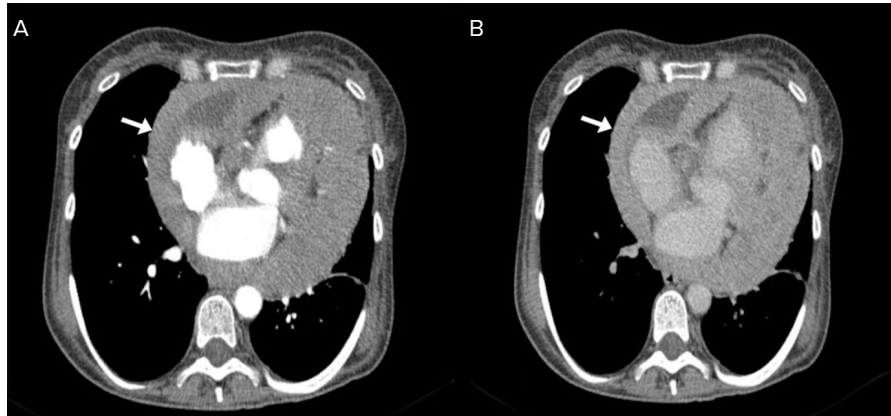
Contrast CT scan three months after diagnosis. A. Arterial phase. B. Venous phase. White arrows indicate a slight increase in the circumferential pericardial thickening.
